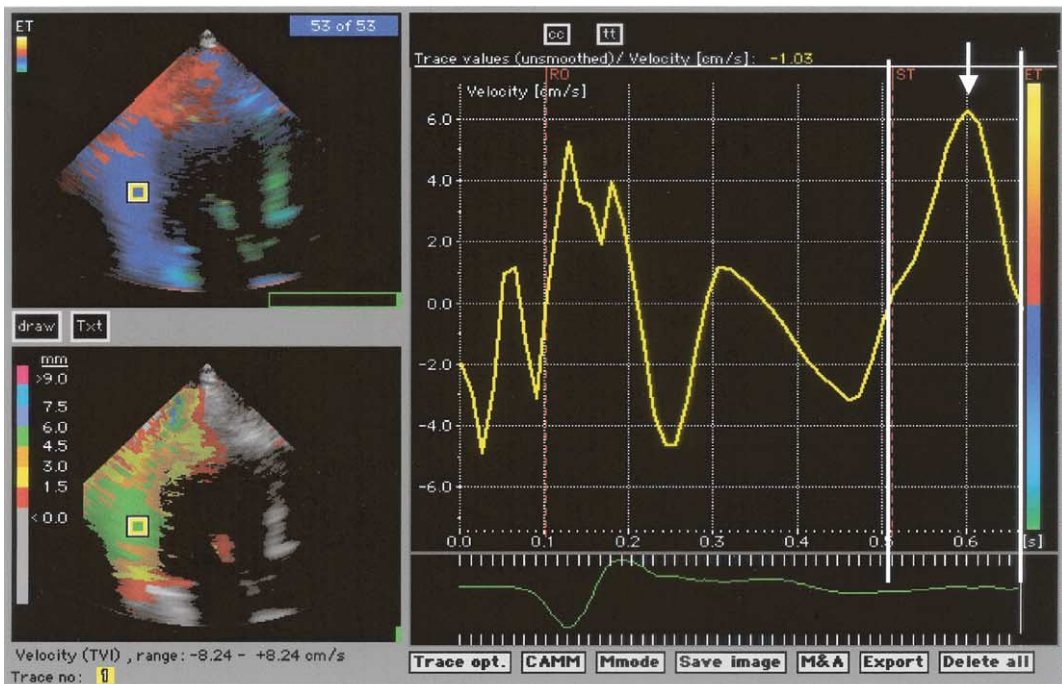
Tissue Doppler image in the apical four-chamber view of a normal subject (upper left panel). (Right panel) The velocity profile during one cardiac cycle obtained at the base of the interventricular septum. The solid lines mark the duration of systole (310 ms), and the arrow indicates the peak systolic velocity (8 cm/s). The diastolic filling of the LV is reflected in the E-wave (E) and A-wave (A). (Lower left panel) Tissue tracking displays, in color-coded format, the regional myocardial shortening (mm) in each segment, calculated automatically as the integral of the digitally stored velocity tracing in systole in each segment.
